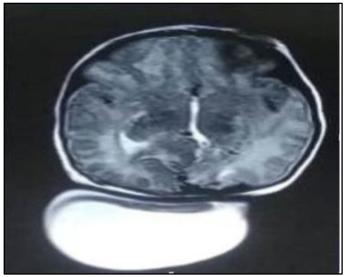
MRI identifies the defect
